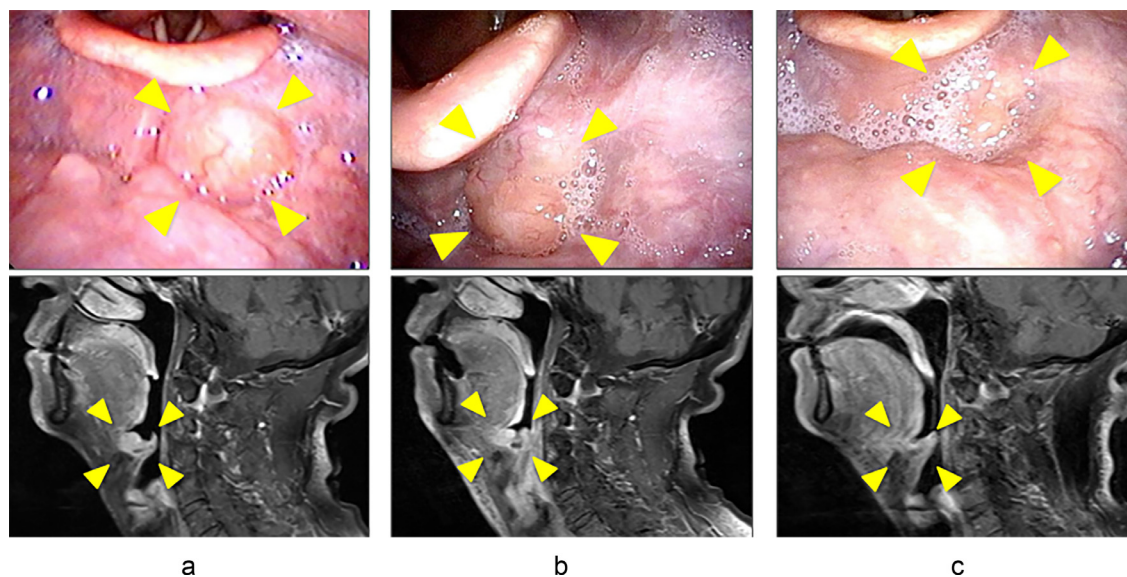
Progress after initial treatment. These are nasopharyngoscopy and contrast-enhanced magnetic resonance images at 1 (a), 6 (b), and 12 (c) months after treatment. After irradiation, the tumor shrank, and the lesion was undetectable at 12 months posttreatment (yellow arrows).
